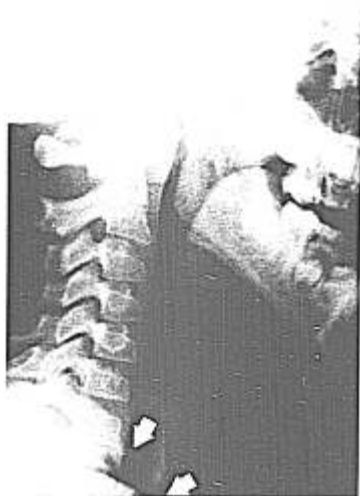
Lateral roentgenogram of the neck, showing herniation of cupola of the right lung above the clavicle during a Valsalva maneuver.
